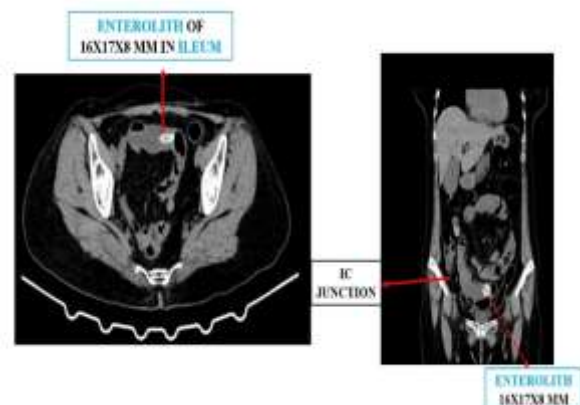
Contrast Enhanced CT Abdomen on the day of admission -Axial and Coronal views-showing the presence of an Enterolith m/s 16x17x8 mm in ileum
